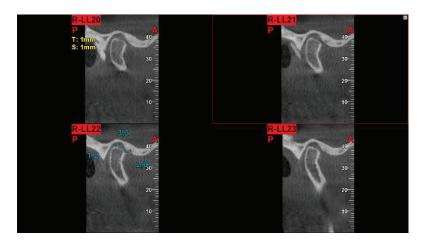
CT scan analysis of the patient's TMJ, born in 1970
